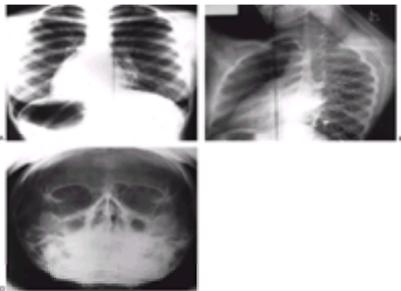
Primary ciliary dyskinesia in a female patient with situs inversus, bronchiectasis, and sinusitis. A: Plain radiograph shows that the cardiac silhouette and stomach bubble are on the right side. An infiltrate silhouettes the left border of the heart. B: Bronchogram of left lung confirms bronchiectasis. C: Sinus radiograph is consistent with sinusitis. (Reproduced courtesy of Manuel Viamonte, M.D., Department of Radiology, Mount Sinai Medical Center, Miami Beach, Florida.)
